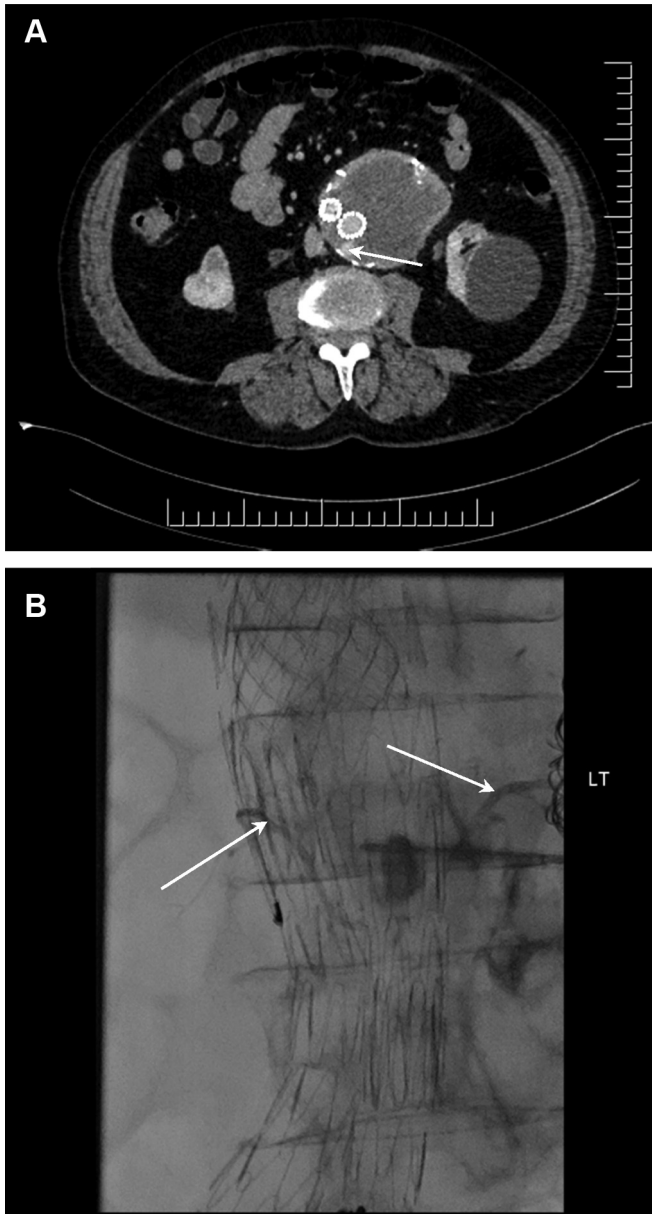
Type II endoleak demonstrated by (A) contrast-enhanced computed tomography (CT) scan and (B) angiography (originating from lumbar arteries).
